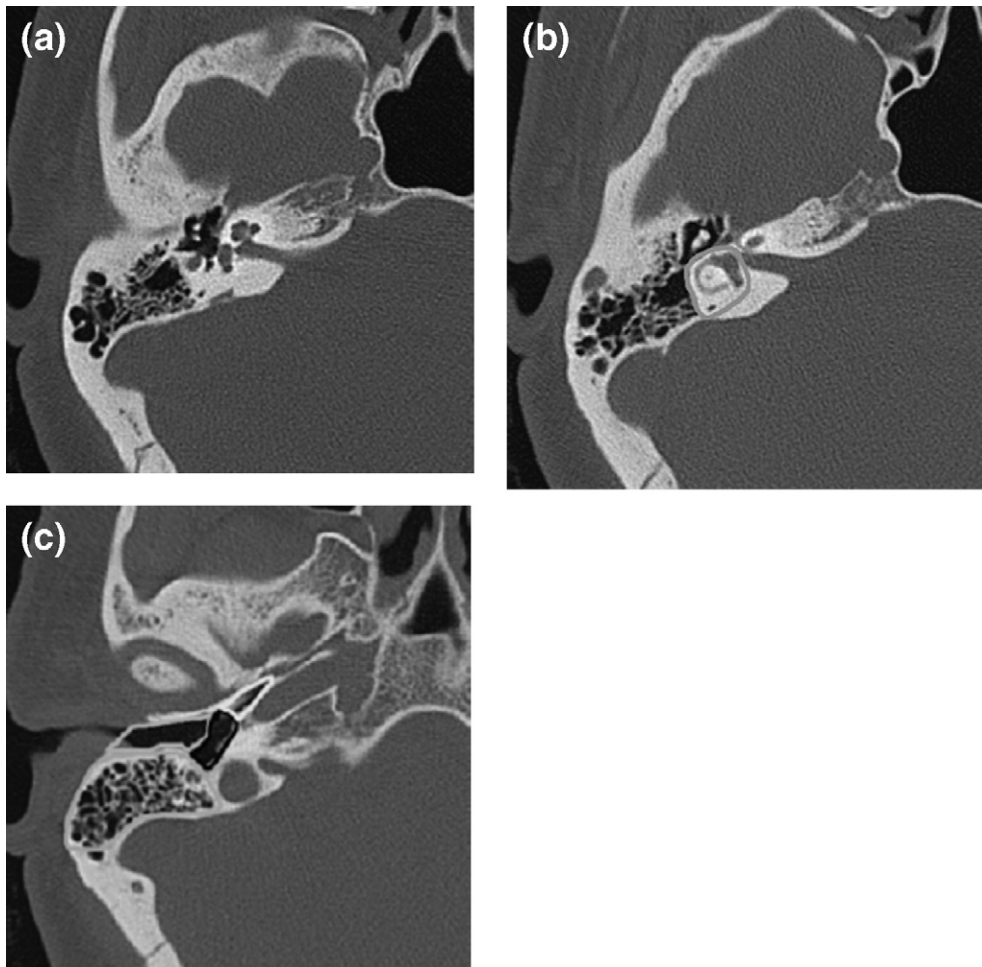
Computed tomography sections used for dose calculations. (a) Midmodiolar cross-section. (b) Lateral semicircular canal. (c) Through the mastoid and tympanic ring.
